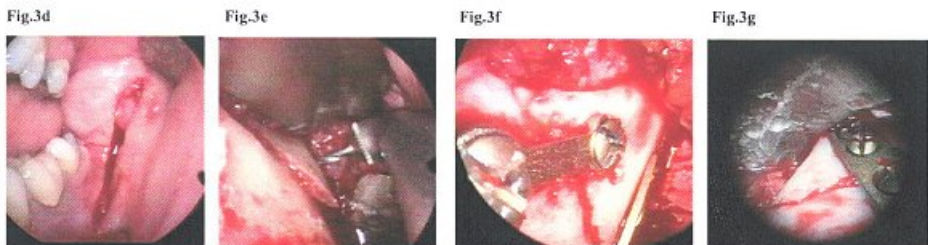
Pre- and postoperative panoramic radiographs and endoscopic view of the fracture site demonstrate the degree of dislocation with shortening of the ascending ramus, and restoration of the vertical height after open reduction and osteosynthesis (Fig.3a, b, c). Limited intraoral incision were used for the endoscopic assisted treatment (Fig.3d). Open reduction and fixation was performed using angulated drill and screw driver without transuccal step incision (Fig.3e). Intraoperatively anatomic reduction was controlled endoscopically at the cranial aspect and in another patient at the dorsal aspect of the ascending ramus (Fig.3f, g). A prototype of a 2.0mm AO 4 hole plate was used at the posterior aspect of the ascending ramus (Fig.3b, f).
